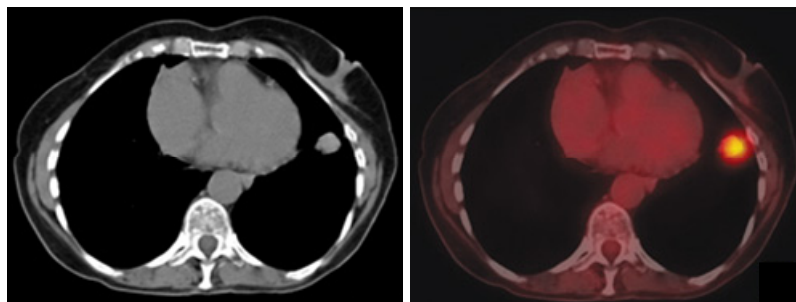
Left) A CT image highlighting a lump in the right lung; Right) The identical PET-CT superimposed image confirming malignancy.
